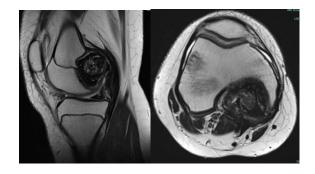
MRI image of right knee
